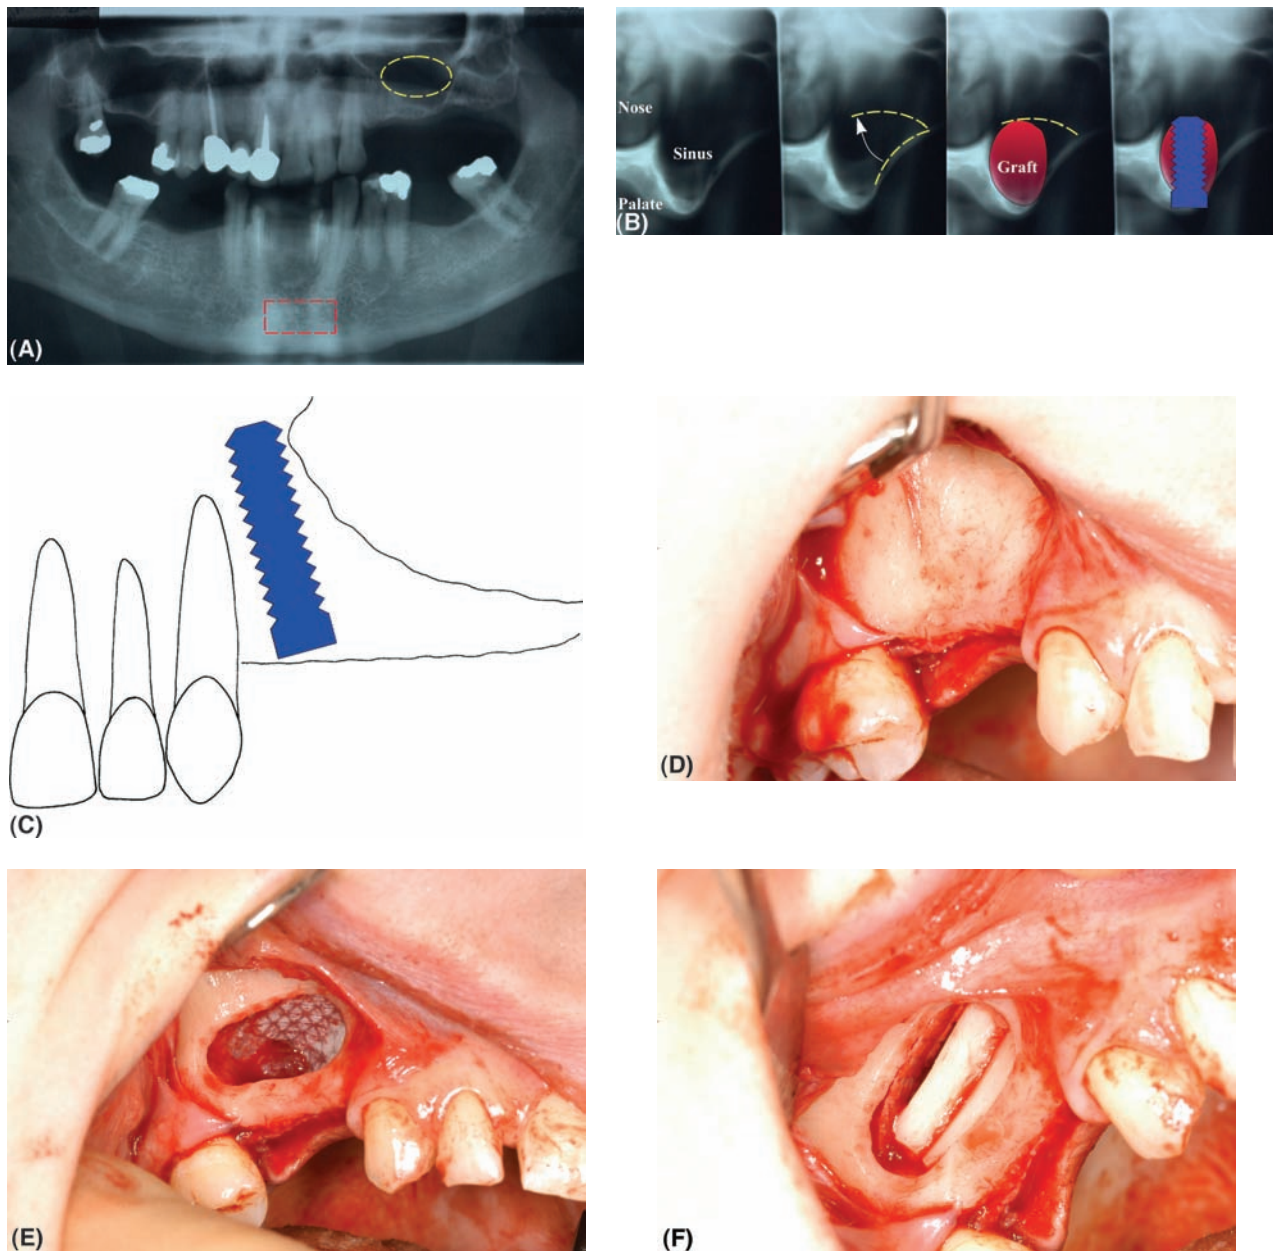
(A) Dental panoramic tomograph of a patient requiring implants in the posterior maxilla. The alveolar ridge has a good intraoral height but the extension of the maxillary sinus on the left side makes it impossible to place more than one implant without using a grafting procedure. There is no indication of sinus pathology or fluid levels/mucosal thickening. Additionally, there would appear to be no bony septa running across the lateral wall. The proposed site for a corticocancellous graft from the chin is also outlined. (B) Sectional tomographs of the patient shown in part A allow evaluation of the space available to elevate the trap door (shown by the yellow line). An indication of the likely volume of graft required can be ascertained as well as the length of implant that may eventually be placed. The amount of residual alveolus in this case would not be enough to stabilize the implant at the sinus grafting stage. Implants would be placed as a separate procedure three months later. (C) Placement of a single implant into the residual alveolus distal to the upper left cuspid is possible for the patient shown in part A. This may be enough in patients with a restricted smile line or in low load situations but is rarely the treatment of choice unless solely replacing the upper second bicuspid. (D) A preoperative view of the lateral wall of the sinus. Here the antral wall is thick and there is no indication of where the sinus cavity lies, often shown by a bluish appearance where the bone is thinnest. (E) The window has been prepared with an acrylic bur and the membrane has been elevated. The membrane has not remained intact and the fenestration created in it has been protected with a resorbable membrane. There is not enough residual alveolus (5 mm) to allow simultaneous sinus lift and implant placement, therefore a graft will be placed into the void created. (F) Residual space within the cavity is packed with autogenous bone, here sheets of bone have been recovered from the ascending ramus of the mandible. (G) Further bone material including osseous coagulum is placed around the graft and on the buccal aspect of the void. The graft may be covered with a resorbable membrane on the buccal aspect to ensure it remains within the void. The flap is then sutured back into place. (H) Preoperative radiograph showing limited bone height in the posterior maxilla. (I) Postoperative radiograph after a sinus lift has been performed in the upper left quadrant. The new level of the sinus floor in relation to the installed implants can be seen. Enough residual alveolus was present in the upper right quadrant to allow implant placement without grafting. (J) Large blocks of corticocancellous graft material may be stabilized by placing implants through both the residual alveolus and the graft. Ideally the graft should be orientated so that the cortical plate is superior allowing good fixation of the apices of the implant.
